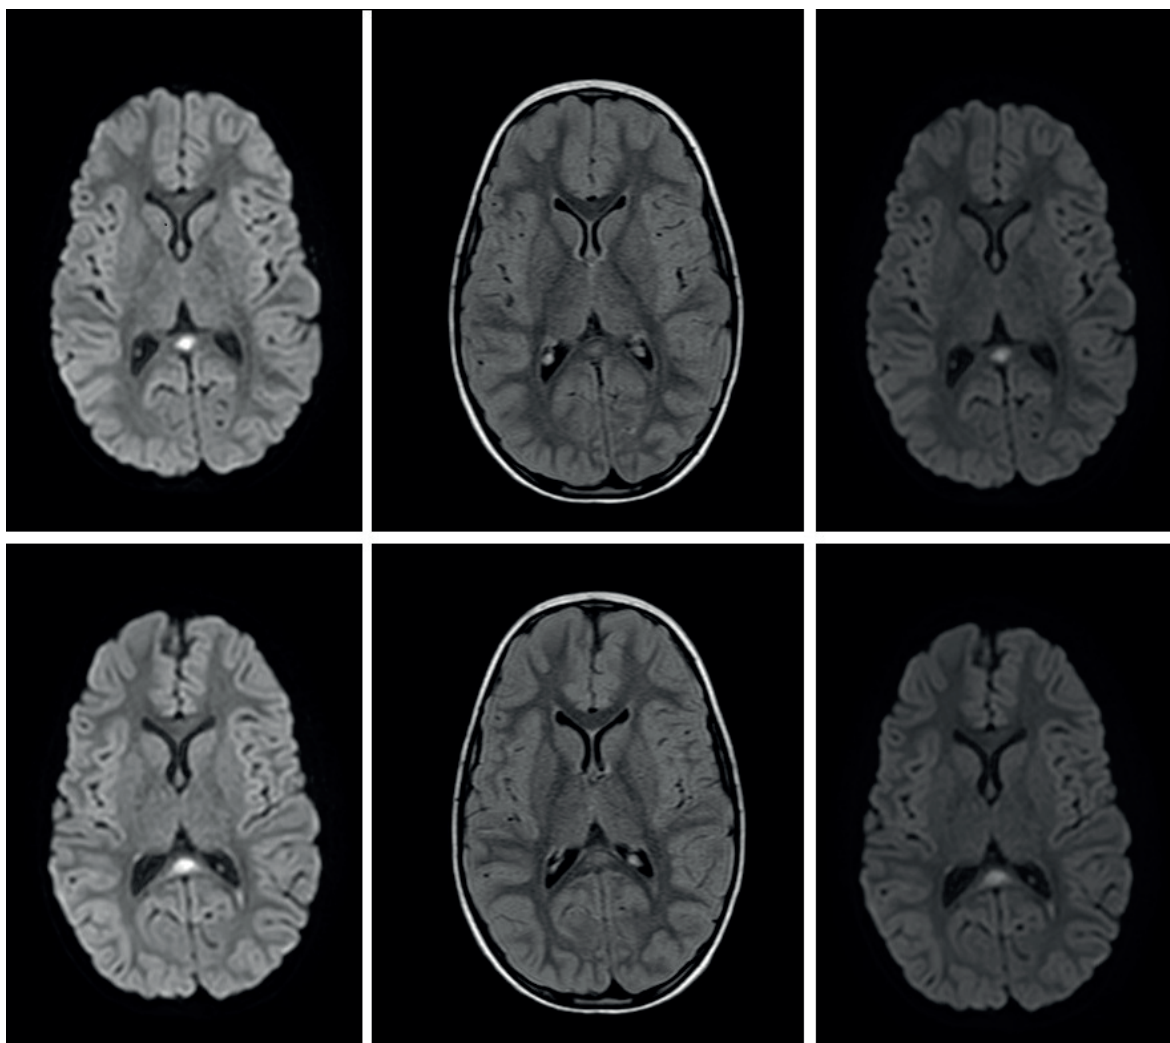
MRI imagines on day 2 with hyperintensity in the SCC.
